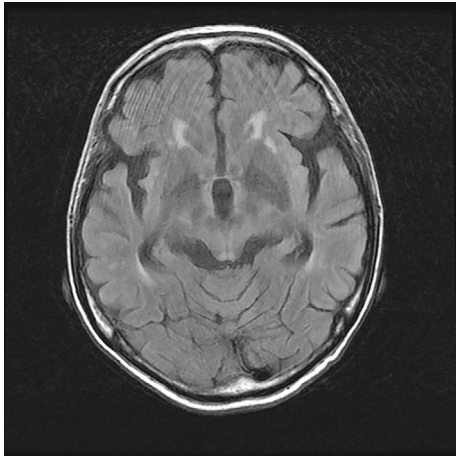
Cranial fluid-attenuated inversion recovery-magnetic resonance imaging shows periaqueductal hyperintensities.
